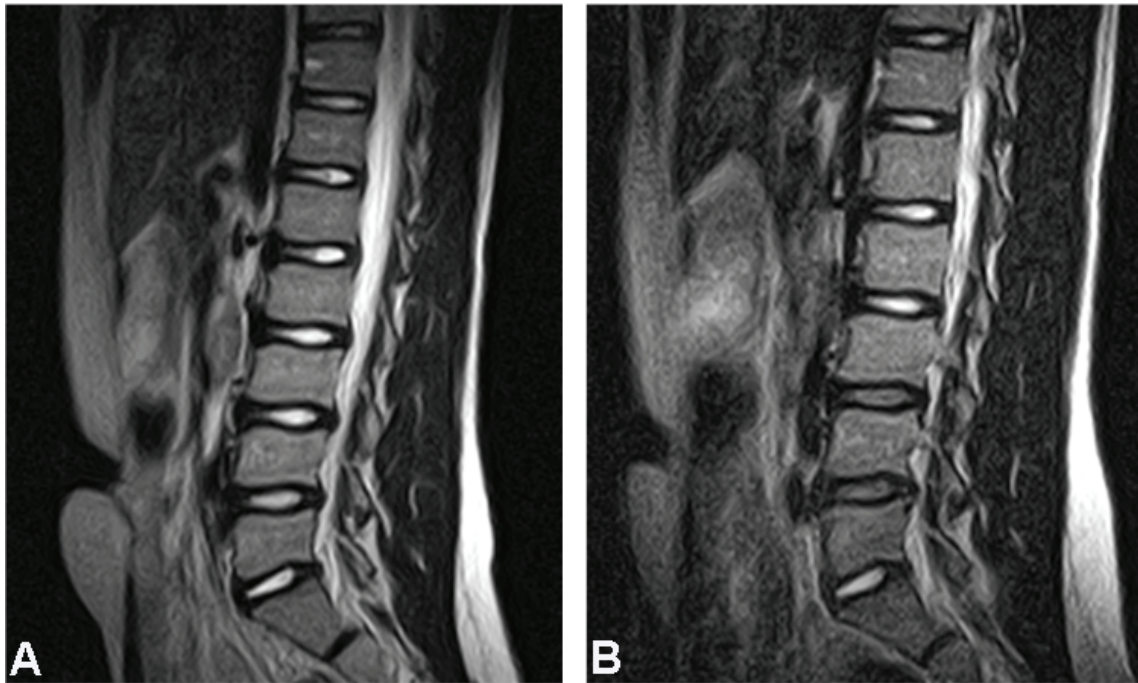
A 15-year-old boy with lumbar disc degeneration progression. A=baseline MRI, disc signals and contour normal, defined as subject without DD B=follow-up MRI, disc signal decrease and a new herniation at L4/L5, defined as subject with DD and DDP.
